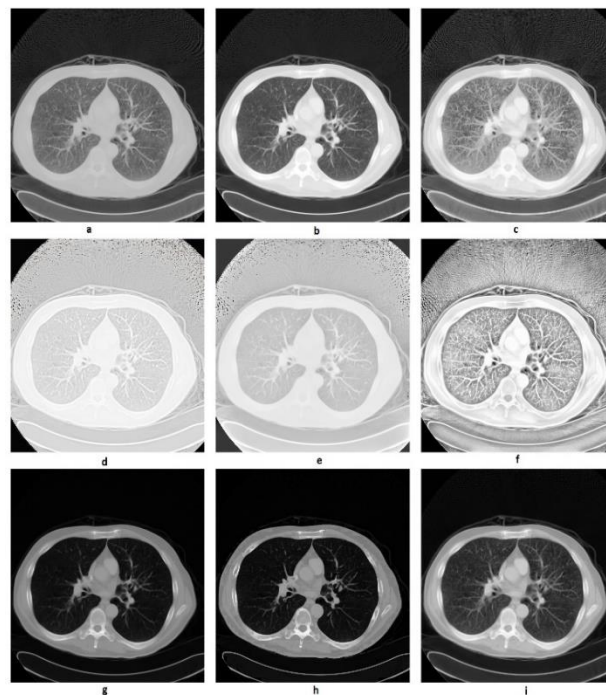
Enhanced test CT image of Lungs2 by a) Reinhard (b) Kim (c) Khan (d) Li (e) Liang (f) Shibata (g) Al-Ameen (h) Gandhamal (i) Proposed, in the reading order.
